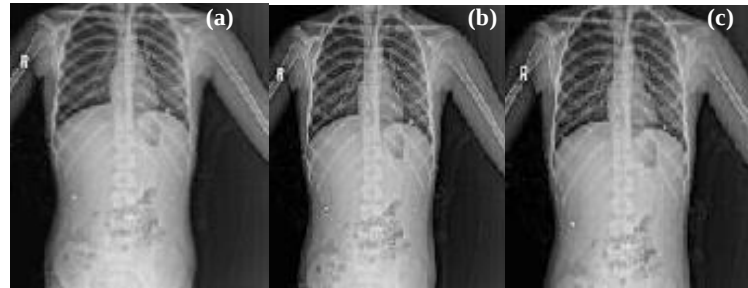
Gray Medical X-Ray Image with $X=0.1$; $U=1$: (a) Original X-Ray image, (b) Encrypted X-Ray image, and (c) Decrypted X-Ray image
